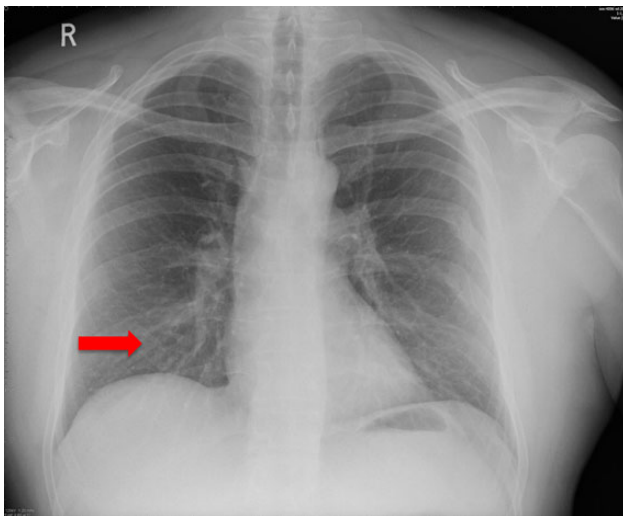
Plain AP chest radiograph showing typical reticulonodular shadowing.
